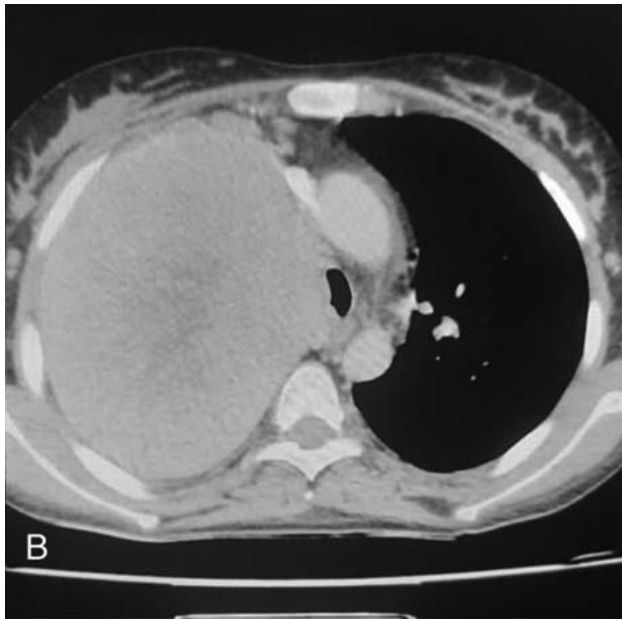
Chest CT axial sections with (A) mediastinal precontrast, (B) mediastinal post contrast and (C) parenchymal window showing right heterogeneously enhancing lung tumour.
